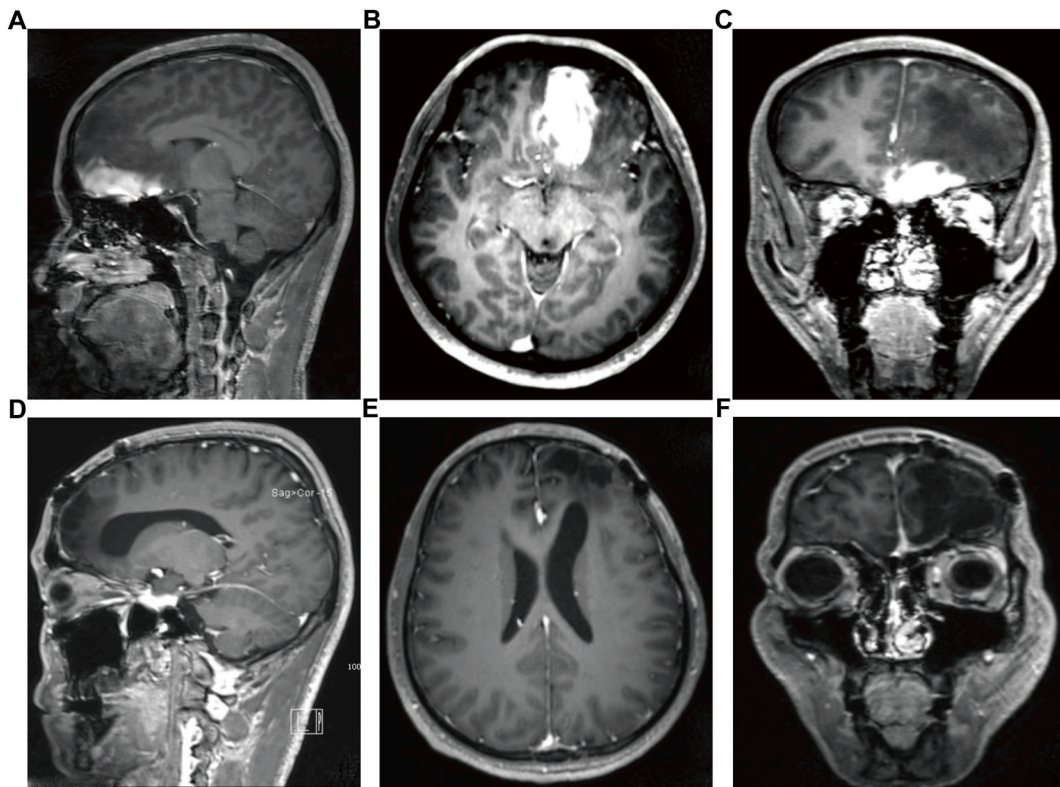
Pre-operative images of the intracranial granuloma. (A–C) Axial, Sagittal and coronal T1-weighted contrast-enhanced sequences MRI showed the homogeneous enhancement space-occupying lesion in the left frontal lobe. (D–F) Axial, Sagittal and coronal T1-weighted contrast-enhanced MRI images demonstrated achieve the gross total resection of the tumour.
